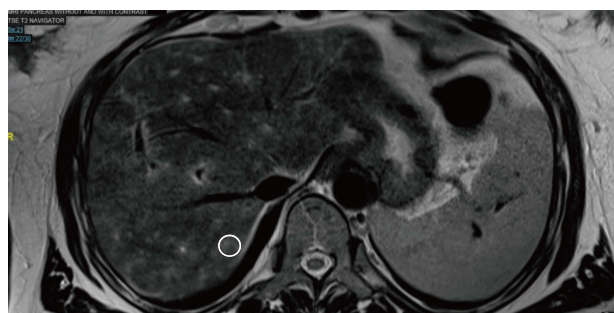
Magnetic resonance imaging pancreas with contrast, T2 imaging. The heterogeneous T2 enhancement (hyperintensities, white patchy areas, one circled) are present throughout the liver parenchyma.
